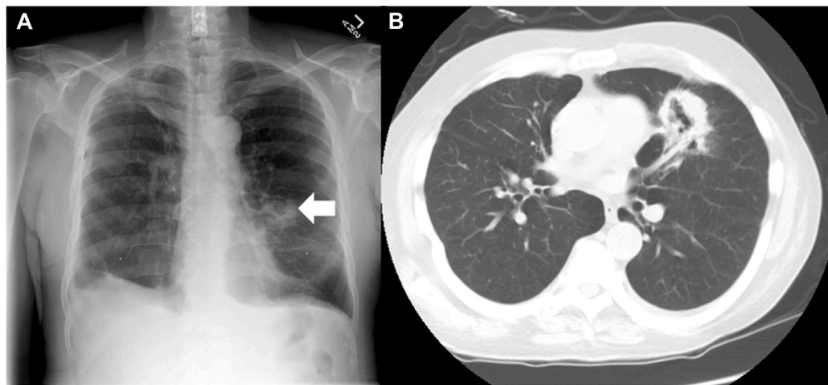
1A. Postero-anterior chest x-ray demonstrating the cavitated lung mass in the left upper lobe (white arrow). 1B. Non-contrast Computed Tomography demonstrating cavitated lung mass in the left upper lobe (3.7 × 2.6cm) without enlarged mediastinal or hilar lymphadenopathy.
